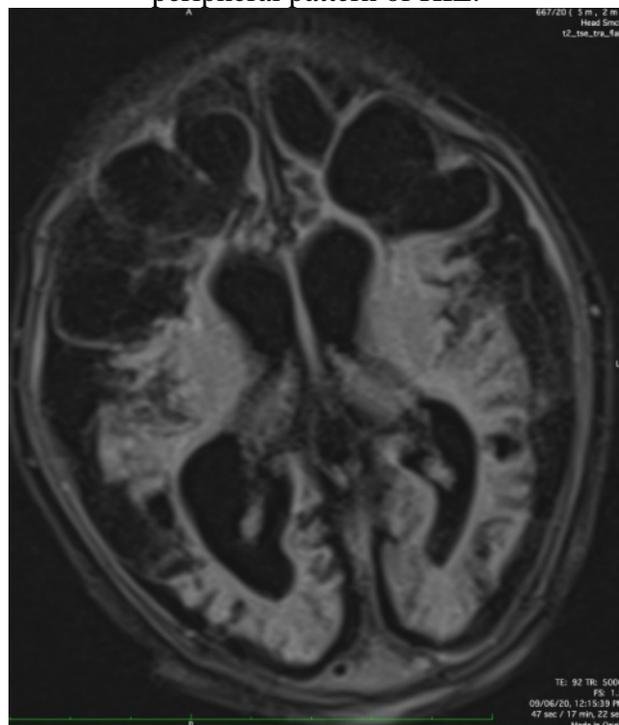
Axial FLAIR MR images showing cystic encephalomalacia involving the bilateral cerebral hemisphere with volume loss and compensatory ventriculomegaly of the same above mentioned patient.
